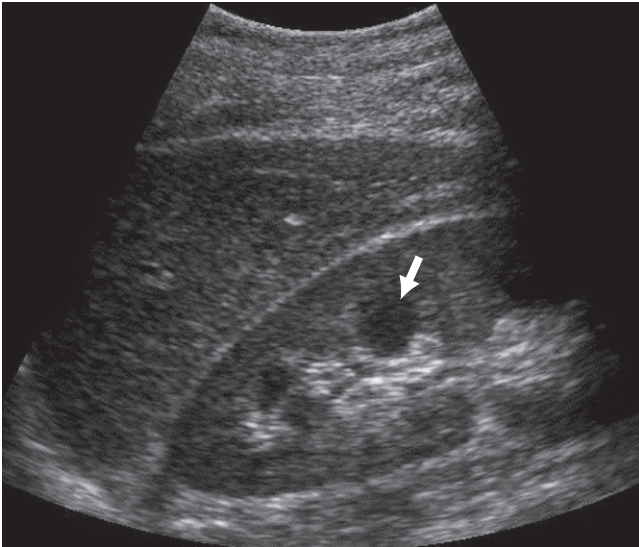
Real-time ultrasound image demonstrates a normal right kidney seen along with the right lobe of the liver. Normal liver is more echogenic than the kidney. Hypochoic renal medullary pyramids are seen (arrow).
